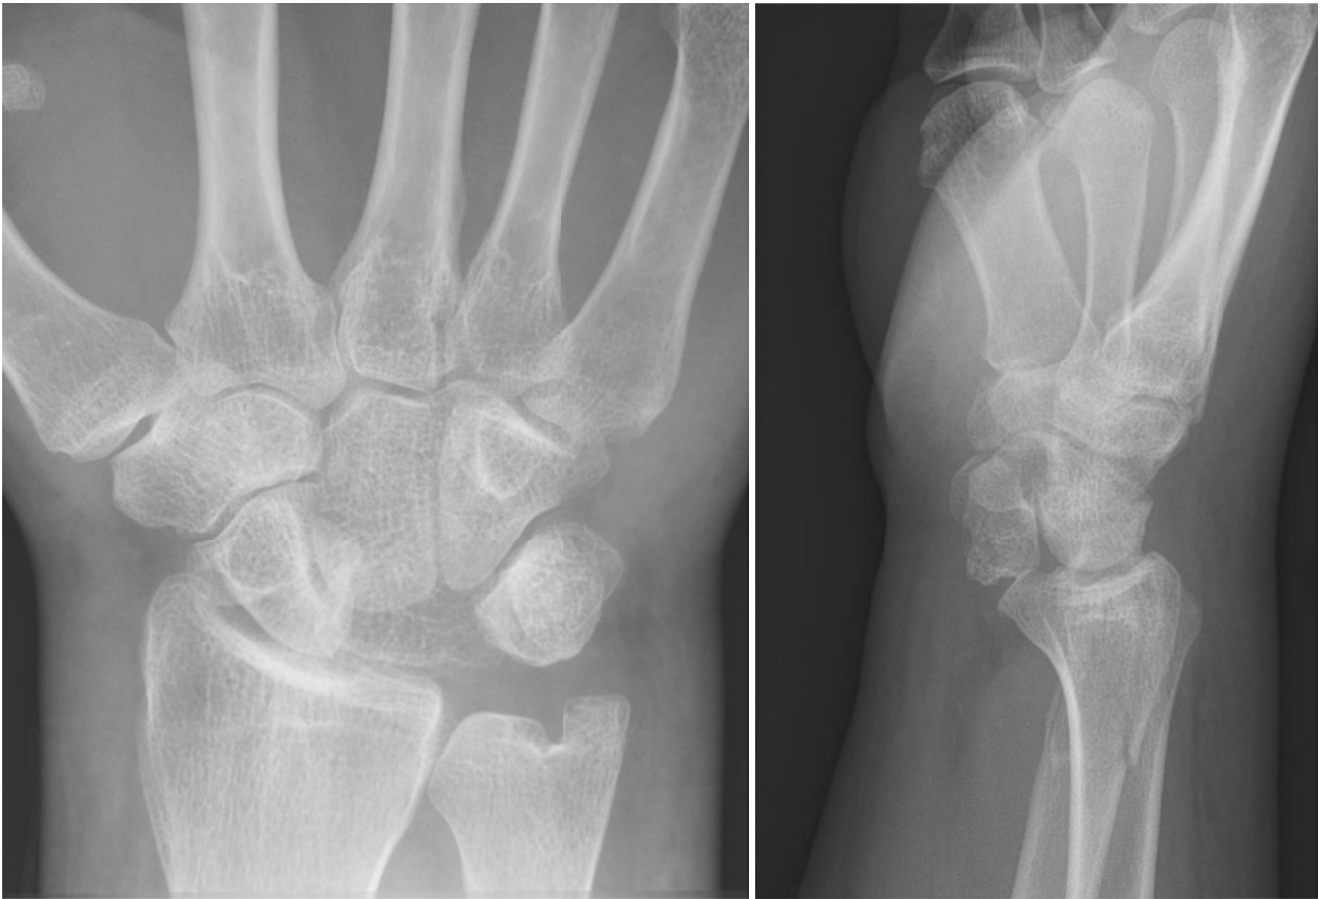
Frontal and lateral radiographs demonstrate volar dislocation of lunate. Notice disruption of carpal arcs on the frontal view. Additional fracture of distal radius is visible on the lateral radiograph
